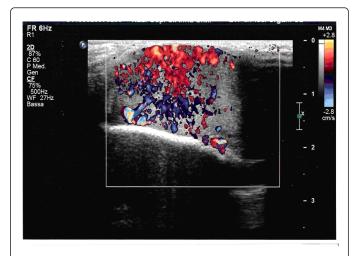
Ultrasound shows the intense arterial and venous vascularization of the lesion and the slight vascular pedunculation with possible intra-cranial connection.
